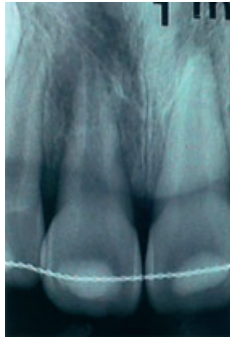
Radiographic examination of the right maxillary central incisor with extensive osteitis and images compatible with inflammatory root resorption (bowl-shaped) 1 month after replantation.
